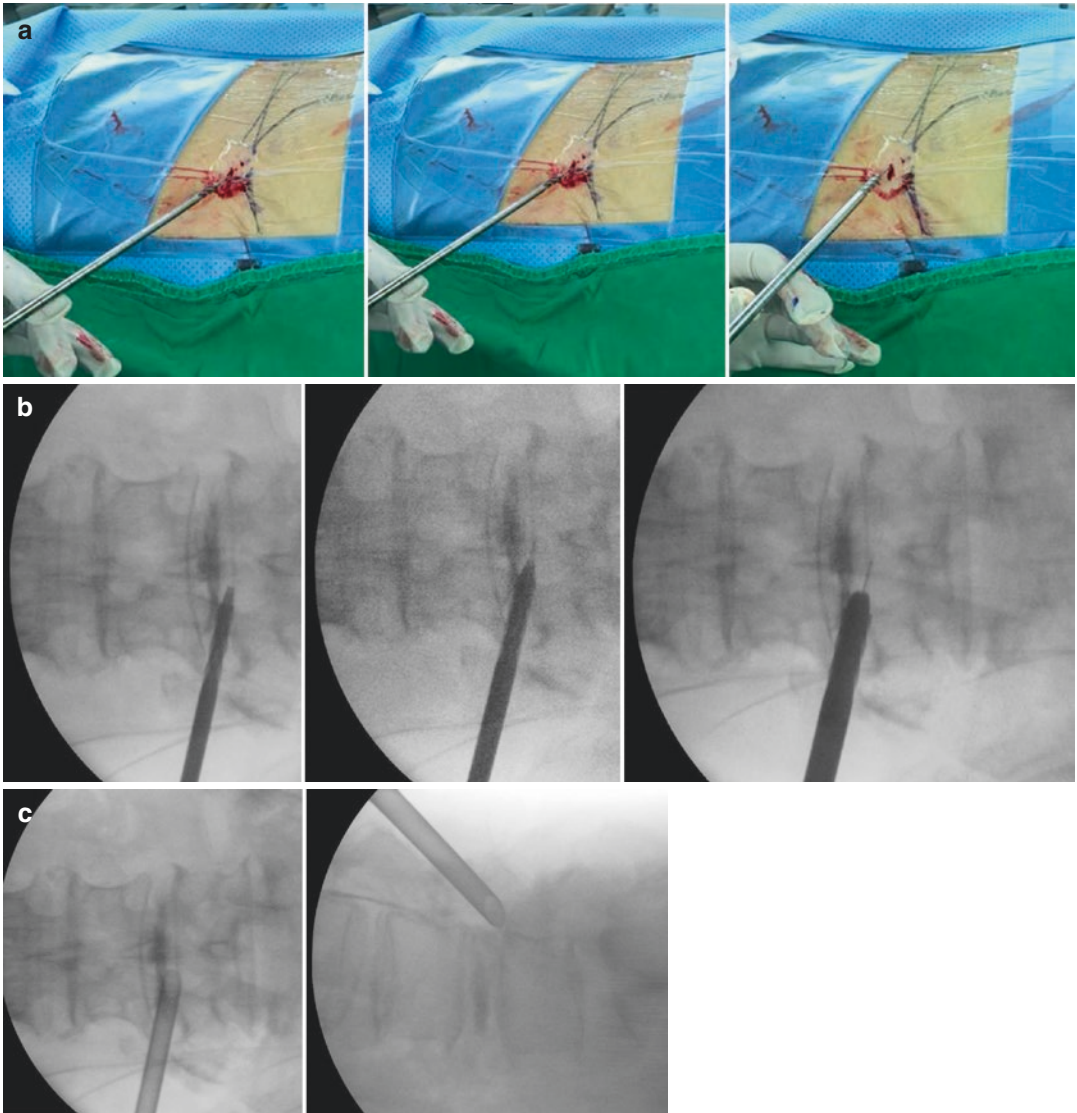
Sequential reaming (a) intraoperative photos, (b) intraoperative radiographies and (c) the location of working cannula on the target point
